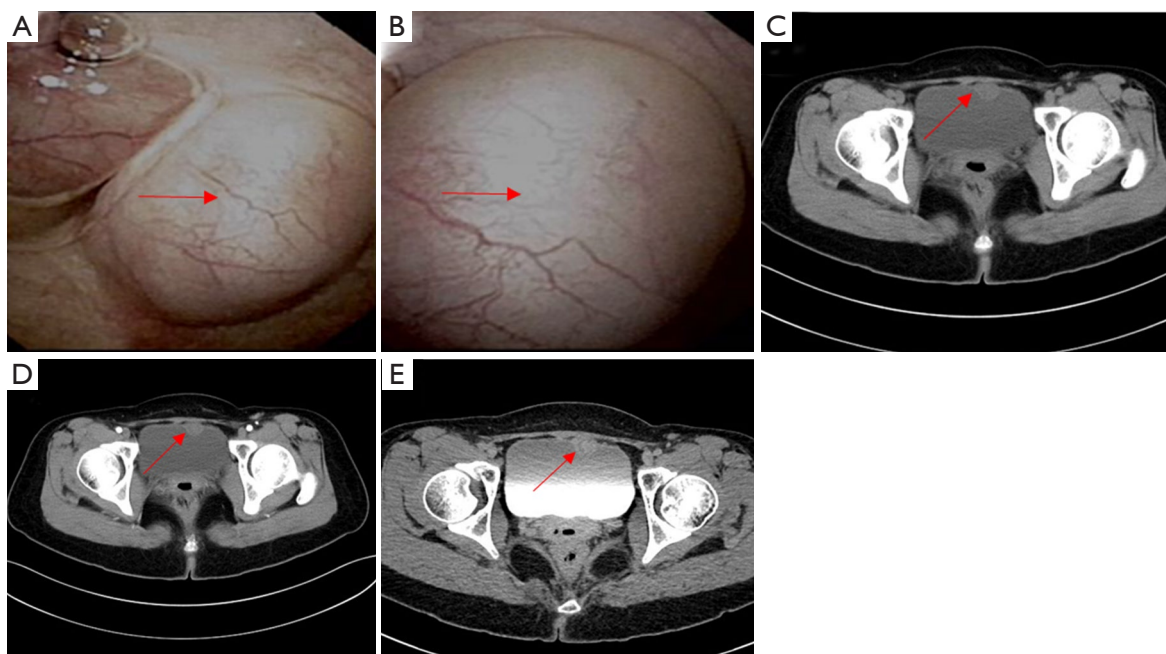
Preoperative examination. (A,B) Flexible cystoscope revealed a 3.5 cm × 2.0 cm mass on the anterior top of the bladder. (C) Non-contrast CT showed a slightly high-density mass with a CT value of 41 HU. (D) Enhanced CT demonstrated the mass was slightly enhanced with a CT value of 79. (E) The mass can also be seen in the excretory period. Arrows indicate the location of the tumor.
